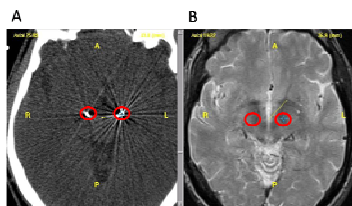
Axial projection of the (A) postoperative stereotactic CT (slice 25 of 85, 43.0 mm) matched with (B) preoperative stereotactic MR (slice 19 of 22, 36.9 mm) of one representative patient. The two red circles represent the electrodes in the two images. The same software used for preoperative planning procedures was used to match the two images.
